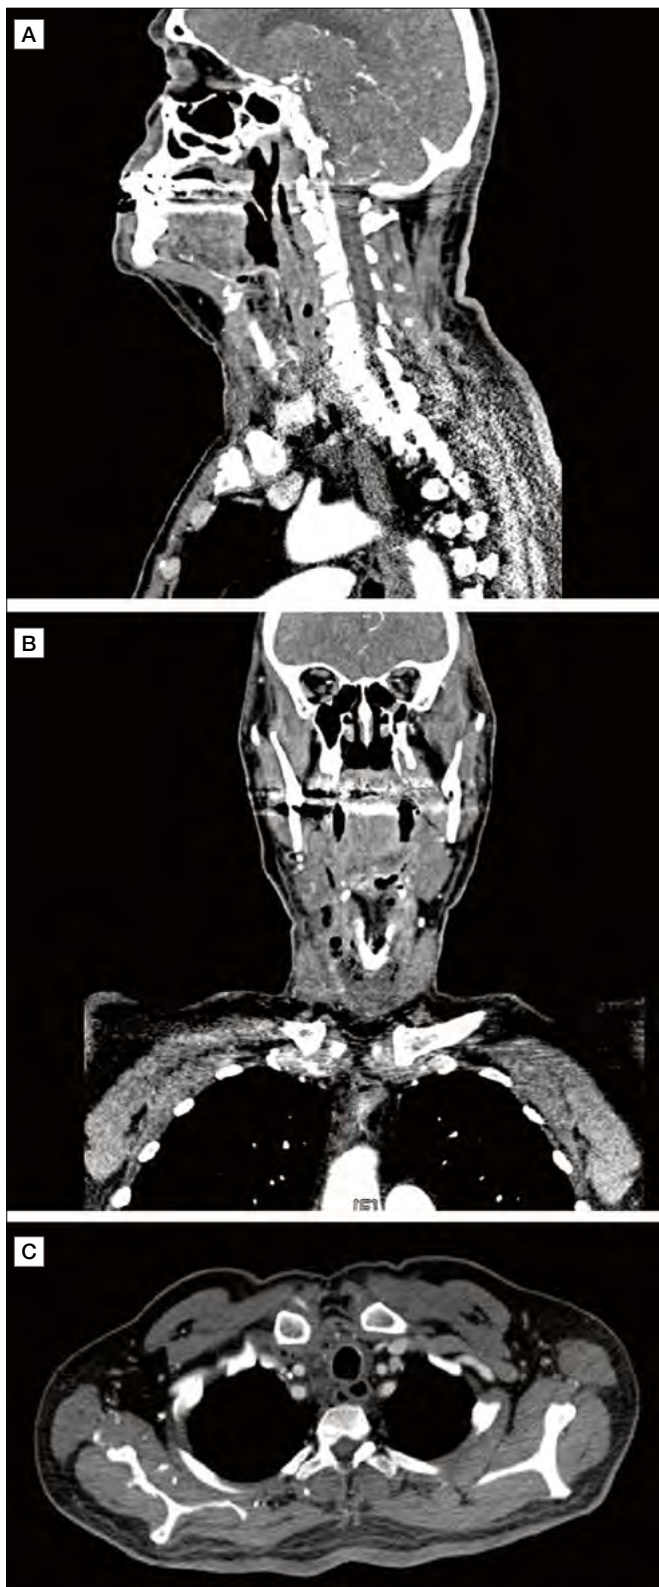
Odontogenic abscess of the upper right arch, partial obstruction of the upper airway. The head, neck and chest CT scan, with contrast medium, documented a phlegmon that reached the mediastinum, through the perivisceral space. (A) coronal plane; (B) sagittal plane; (C) axial plane.
